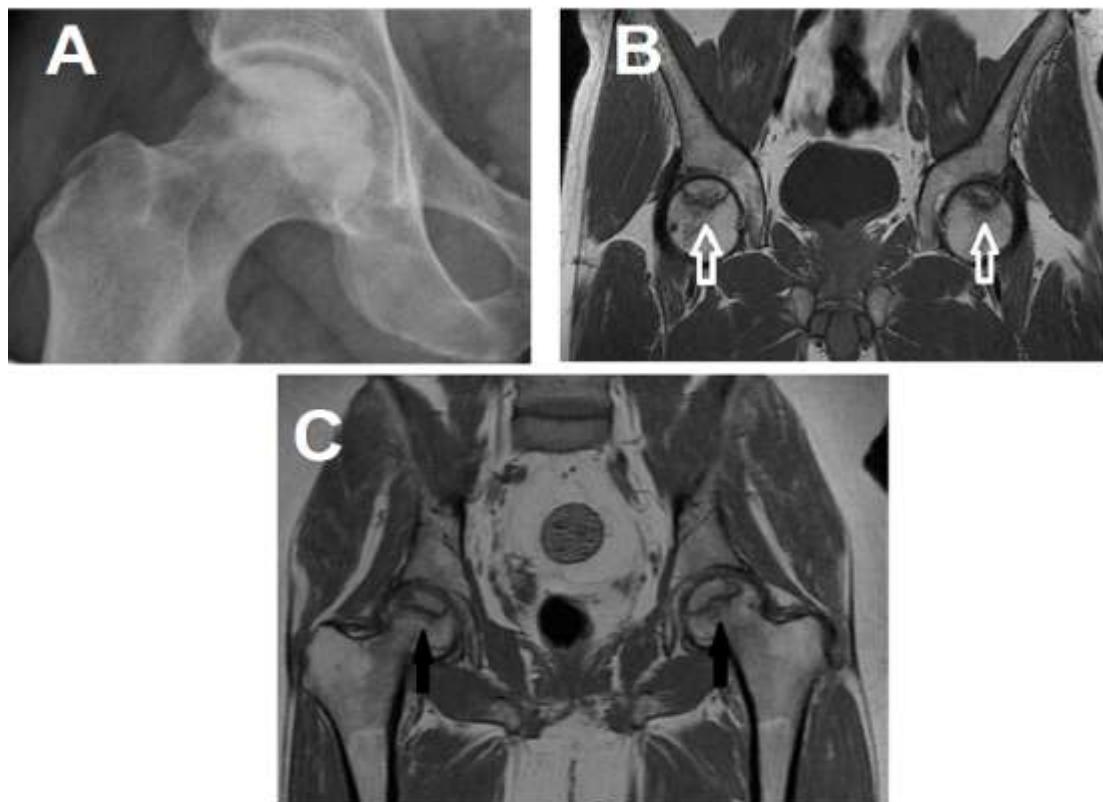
Sensitivity of Imaging Modalities (X-Ray vs MRI)
